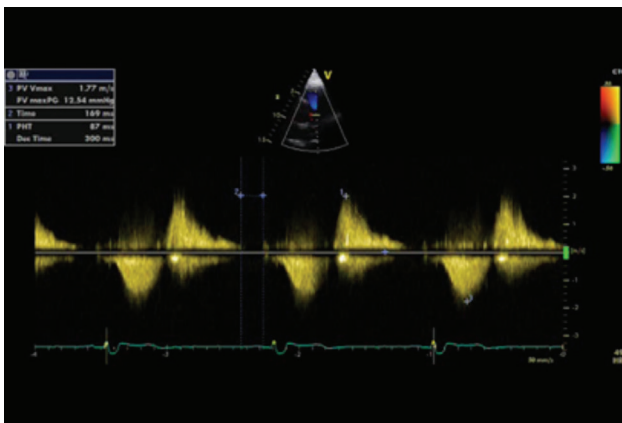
Continuous wave Doppler across the pulmonary valve showing severe pulmonary regurgitation.
